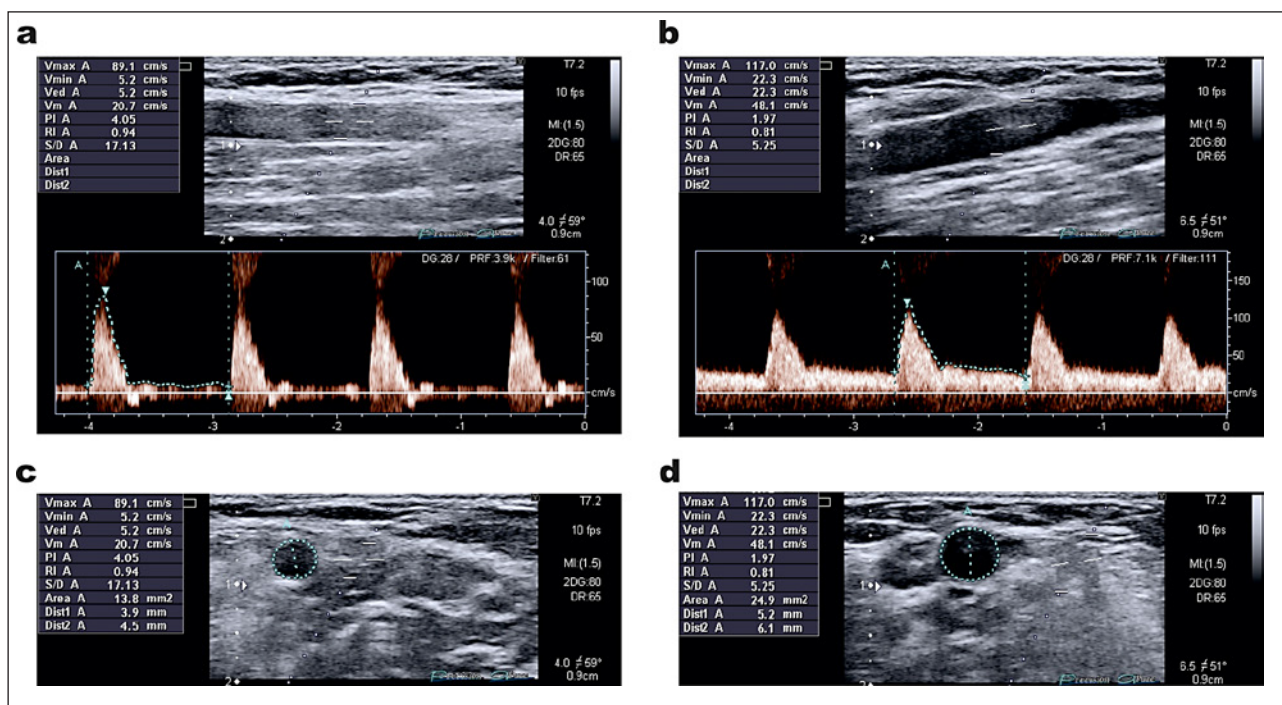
Exemplary sonographic images of patient No. 30. The images were taken at the non-fistula (a, c) and fistula arms (b, d). a, b Doppler spectra of the A. brachialis recorded in the duplex mode. c, d The cross-sections of the A. brachialis as measured in B-mode. For patients' characteristics, see online supplementary Table S2.
